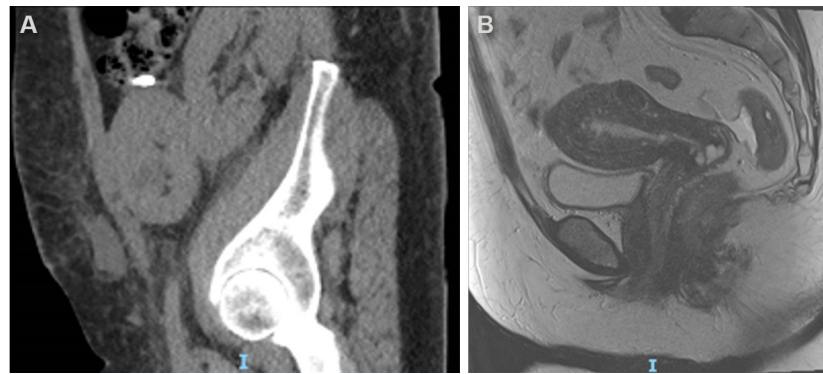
Pelvic sagittal view CT showing the dual kidney transplant taken immediately after the transplantation surgery (A). Pelvic sagittal view MRI showing endometrial lesion confined to the uterus (B).
